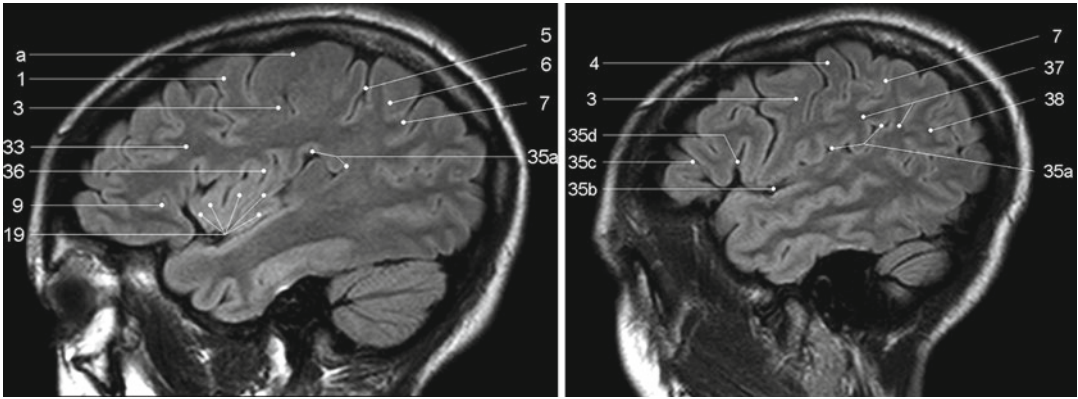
Sagittal FLAIR images. 1 superior frontal gyrus, 3 precentral gyrus, 4 postcentral gyrus, 5 “pars bracket”, cingulate sulcus, 6 precuneus, parietal lobe, 7 intraparietal sulcus, 9 pars opercularis, inferior frontal lobe, frontal operculum, 19 insula (anterior and posterior short insular gyri), 33 medial
